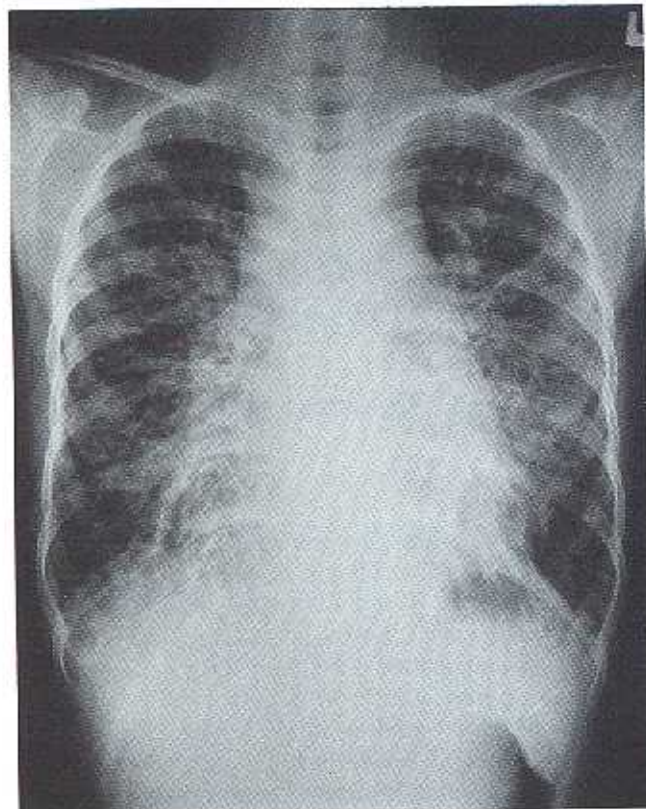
Chest X-ray showing bilateral infiltrates and mediastinal widening. Note Kerley's lines.
